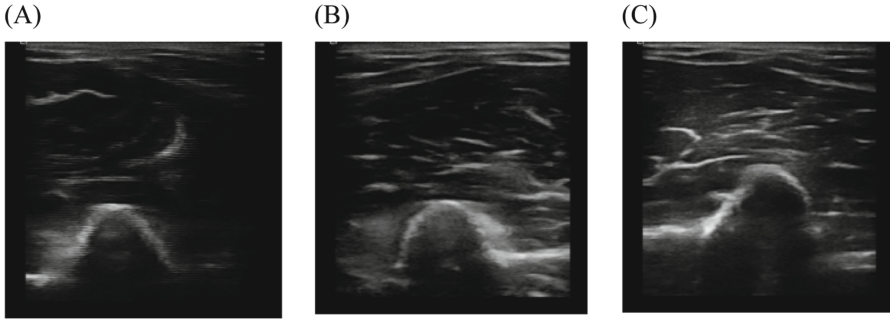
The subject takes the vibration at different frequencies of ultrasound images in 10-min condition (A) 5 Hz; (B) 35 Hz; and (C) 50 Hz.
